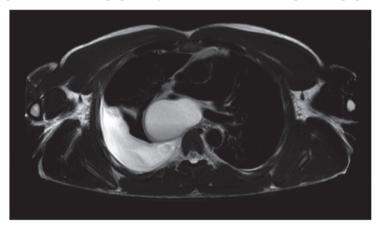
Magnetic resonance imaging scan of the chest (axial view, T2-weighted imaging)
